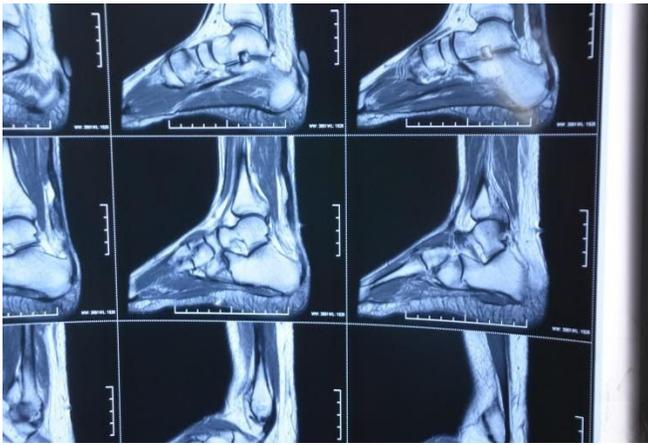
Preoperative MRI showing Achilles tendon tear.
